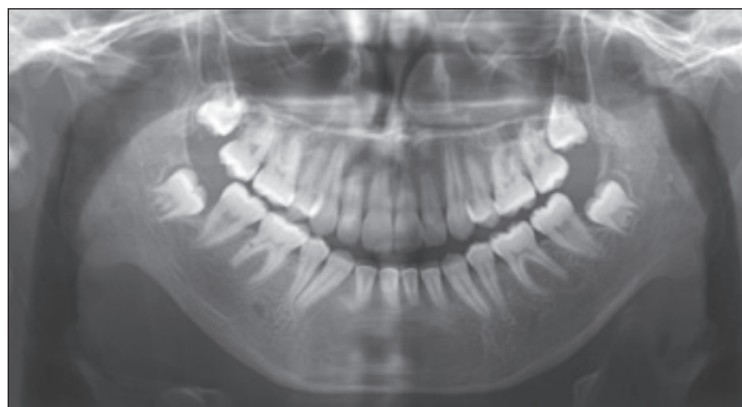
Post-treatment orthopantomogram following initial orthodontic treatment; January 2010.
